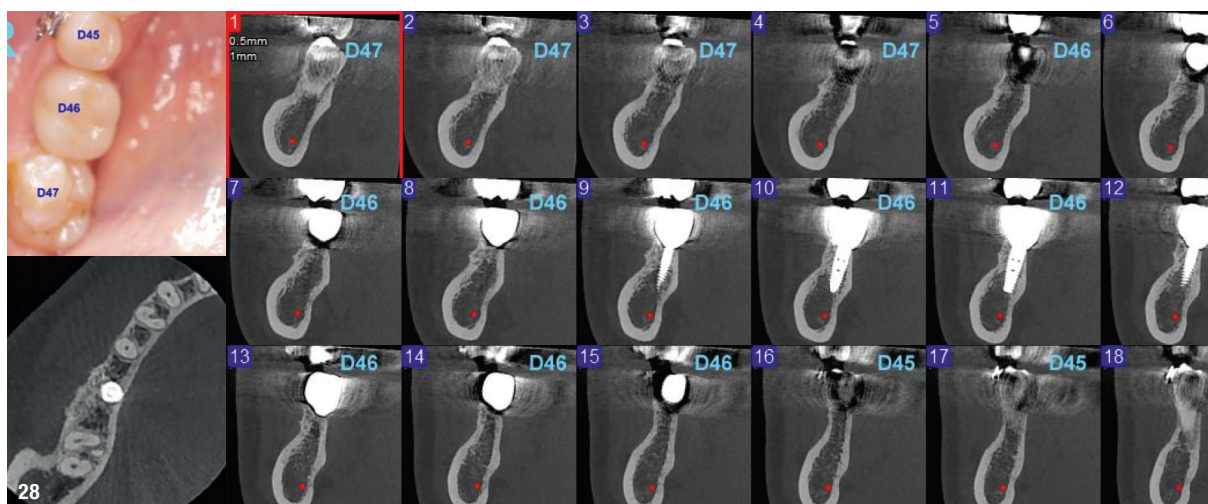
Clinical aspect and CBCT measurements at 36 months post-op.
